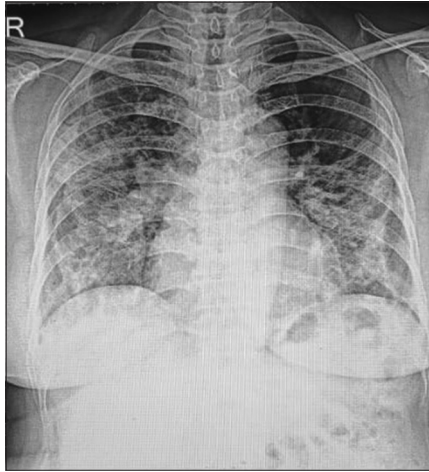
Chest radiograph of case 5 showing Severe COVID pneumonia with relative sparing of left upper zone
